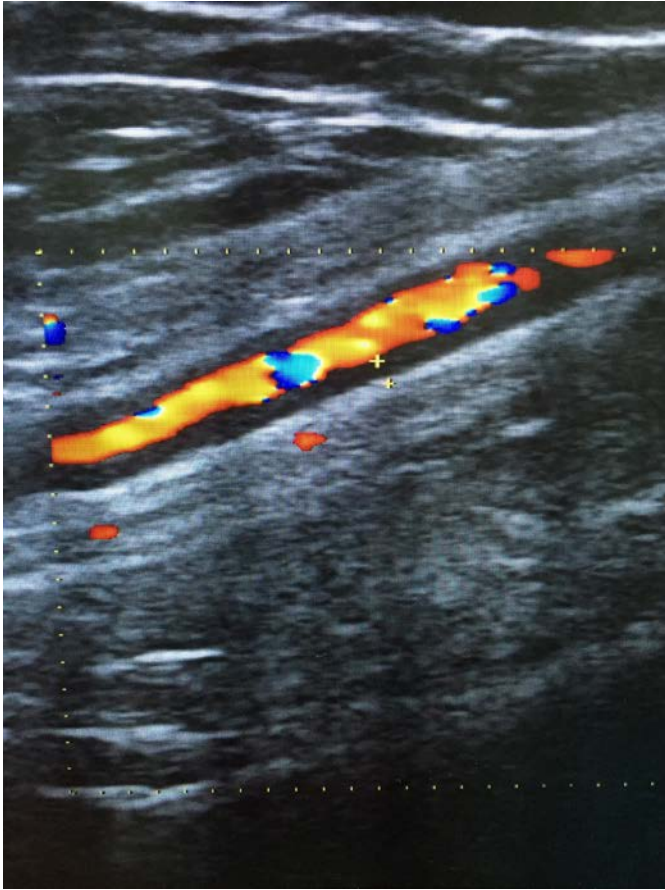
Left axillary artery ultrasound, longitudinal view, at 10 weeks of treatment. Hypochoic wall swelling (halo), size 1.1 mm.
